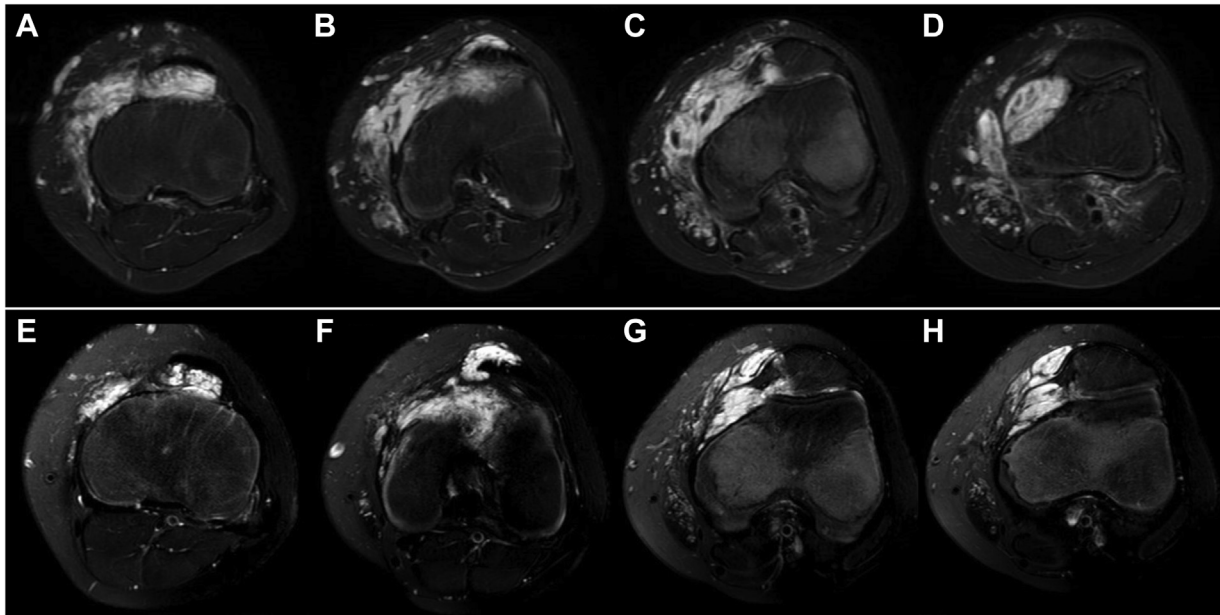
A magnetic resonance imaging (MRI) comparison before and after ablation of a venous malformation (VM) in the lateral aspect of the left knee joint in a 12-year and 11-month-old patient. The VM in the lateral knee joint was the designated ablation area. However, due to the potential risk of joint effusion, patellar ligament injury, and joint instability, ablation was not performed around the patella. (A-D) Preoperative T2-weighted images show the lesion as a hyperintense signal. (E-H) T2-weighted images obtained 9 months after ablation reveal the disappearance of abnormal signals in the treated tumor region, indicating successful treatment.
